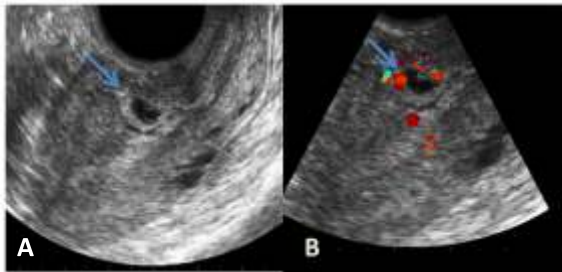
CSP: (A) Anterior low position of GS (5 weeks) in niche of scar suggestive of scar implantation (arrow), (b) Color Doppler shows presence of peritrophoblastic vascularity (arrow)
